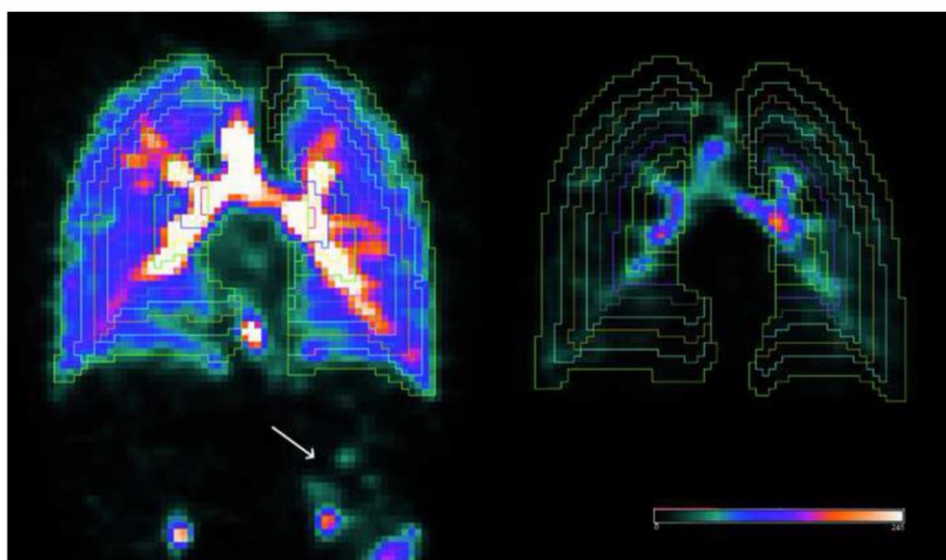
Shell decomposition of SPECT-CT coronal slices at the level of the right hilum for both nebulizers on the same subject, with the same level of brightness. Both lungs were divided in ten shells (coloured lines through both lungs) distributed from the hilum to the lung periphery. The deposition of the radiolabeled particles of aerosol, depicted in colour, is highly increased with the vibrating-mesh nebulizer with its specific valve-holding chamber in comparison to the constant-output jet nebulizer with a corrugated tube. Activity is seen in the stomach with the vibrating-mesh nebulizer (white arrow). Reprinted from (Dugernier et al., 2017), with permission of Springer.
